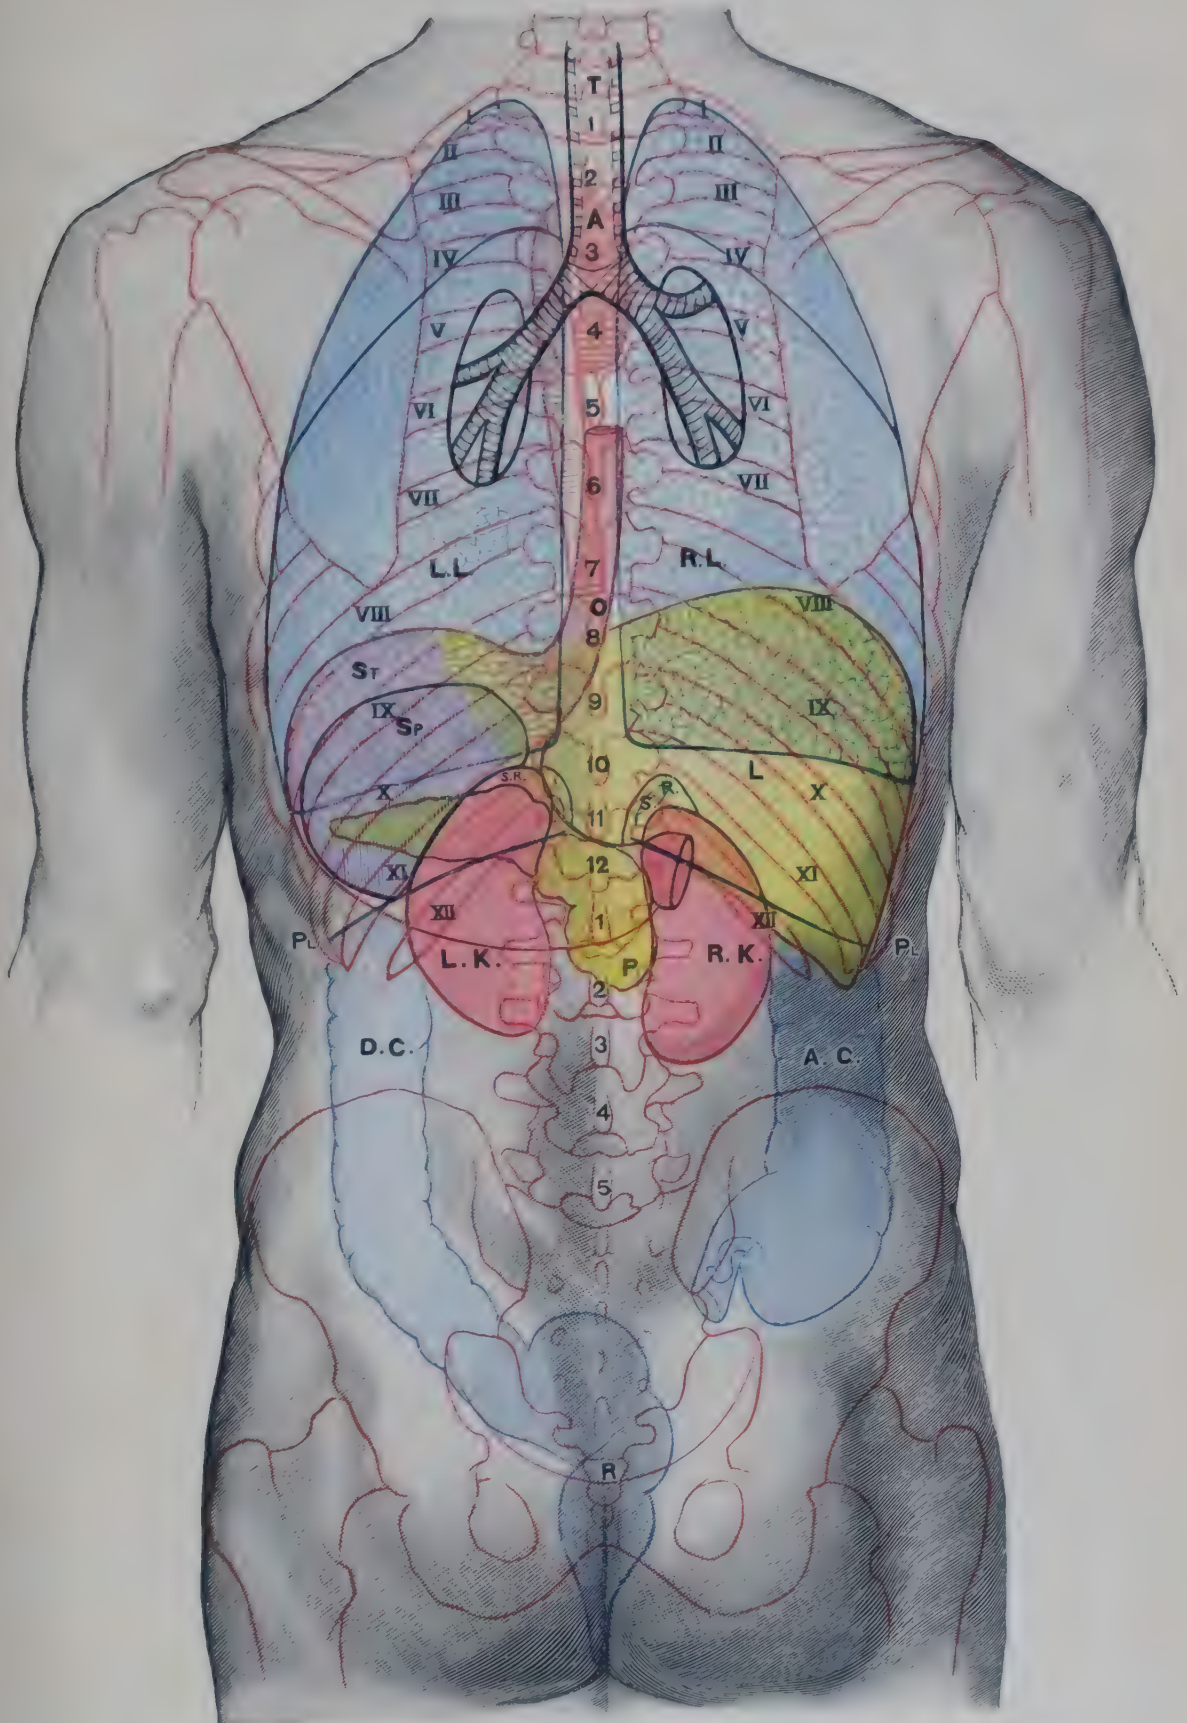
POSTERIOR ASPECT OF TRUNK, SHOWING SURFACE TOPOGRAPHY OF VISCERA.
